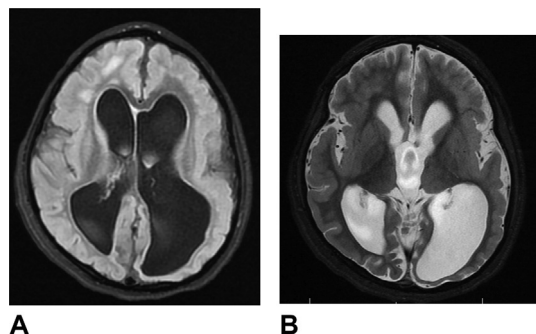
(A) Axial T2 FLAIR MRI brain without contrast of 5-year-old patient with congenital CMV. This image demonstrates severe ventriculomegaly with enlargement of the lateral and third ventricles. There is abnormal FLAIR signal seen throughout the subcortical white matter particularly in the bilateral frontal and parietal regions, right more than left cerebral hemisphere. (B) Axial T2 MRI brain without contrast of 5-year-old patient with congenital CMV. There is evidence of severe polymicrogyria seen throughout the bilateral frontal, parietal, and temporal lobes. Additionally the cerebellar vermis appears abnormally rotated. Sagittal images (not shown) demonstrated severe dysgenesis of the left cerebellar hemisphere and a large posterior fossa cyst.
